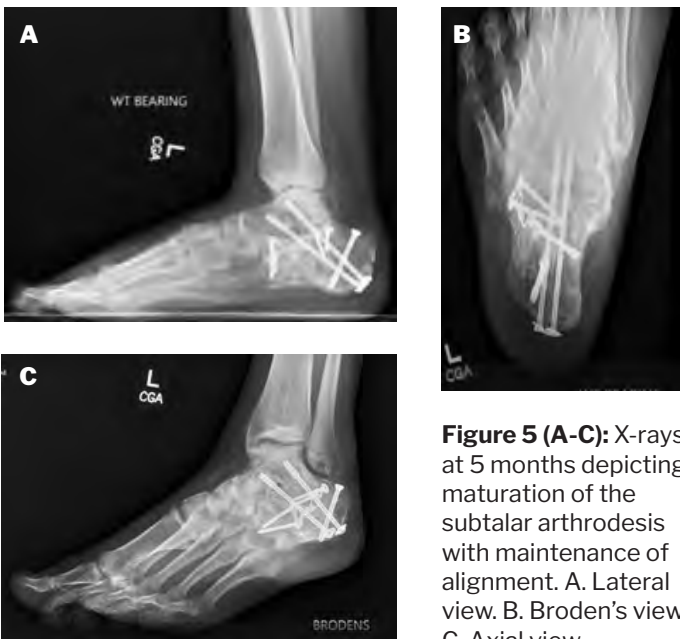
(A-C): X-rays at 5 months depicting maturation of the subtalar arthrodesis with maintenance of alignment. A. Lateral view. B. Broden's view. C. Axial view.
